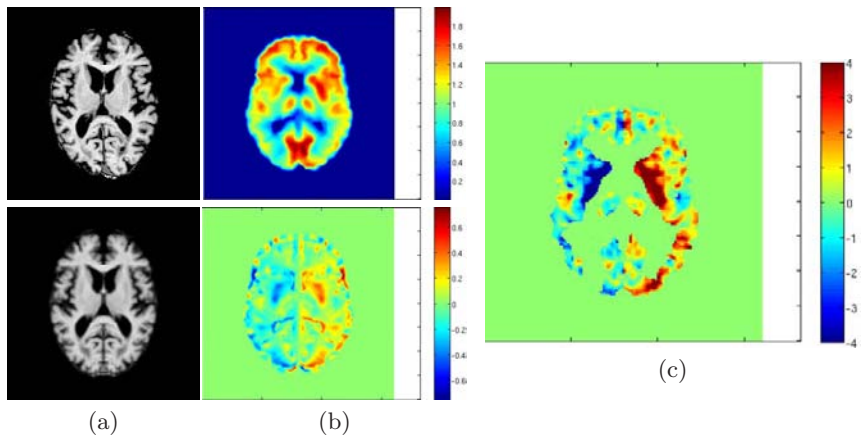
Shown in (a) are original MRI scan (top) and the associated structurally symmetric image (bottom) of a subject with AD. Shown in (b) top is the subjects PET scan. Shown in the (b) bottom is the metabolic asymmetry image mapped in to the atlas space. Shown in (c) is the image of the statistical significance of metabolic asymmetry as compared to the normative atlas.
